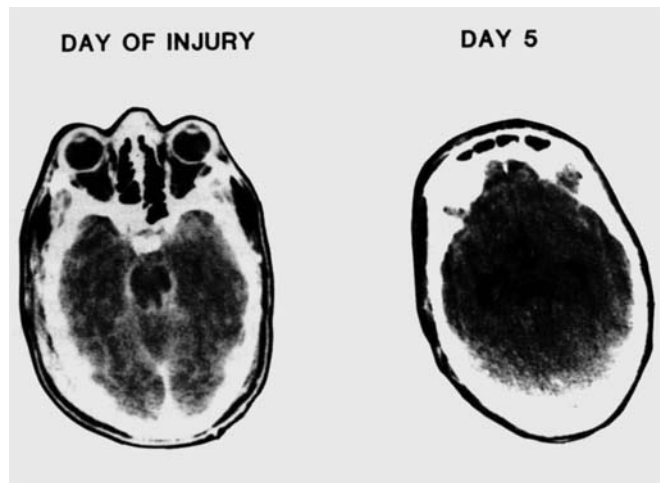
Computerized tomography (CT) scans for a 21-year-old female with severe closed head injury on the day of injury and on postinjury day 5 showing brain stem level pathology.
